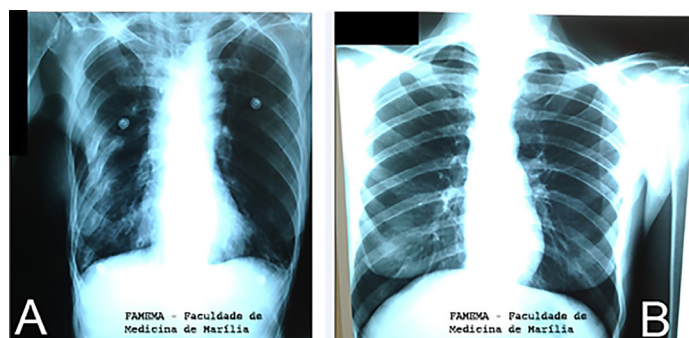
A: Nonspecific radiographic changes presented by Patient 1. B: Patient 2 without significant radiographic changes.
